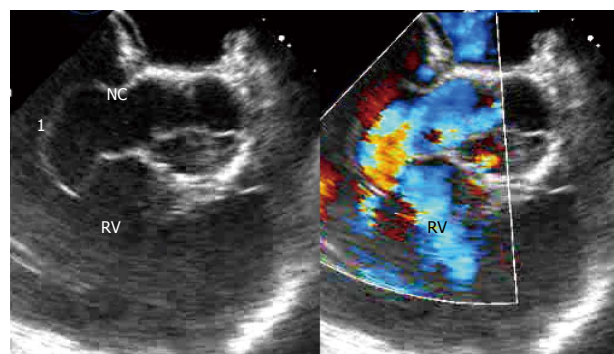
Subsequent transesophageal echocardiogram done, showed a ruptured aneurysm of the noncoronary sinus of Valsalva, that is Windsock in morphology, into the right atrium. A: Sinus of Valsalva defect with; B: Color-Doppler. 1: Windsock aneurysm; RV: Right ventricle; NC: Noncoronary cusp.
